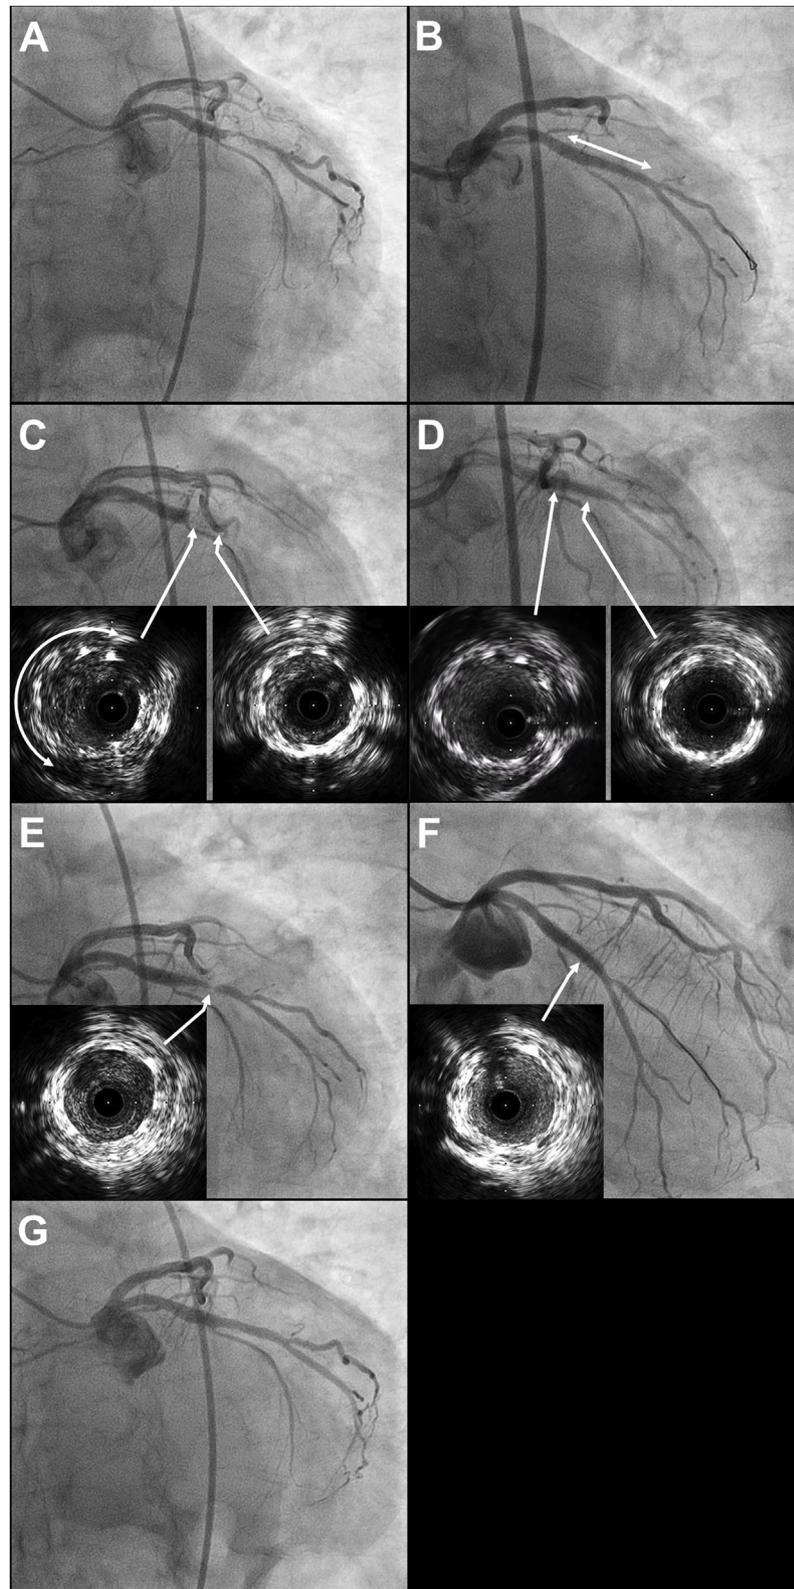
Coronary angiograms and intravascular ultrasound (IVUS) images. (A) Coronary angiography (CAG) demonstrated severe stenosis and haziness of the distal left circumflex coronary artery (LCX) at the time of ST elevation myocardial infarction (STEMI). (B) CAG after bare-metal stent (BMS) implantation in the distal LCX (double arrow) demonstrated good coronary blood flow at the time of STEMI. (C) CAG demonstrated occlusion of the BMS due to late stent thrombosis (LST) 70 days after BMS implantation. IVUS after thrombus aspiration showed good stent expansion and apposition but incomplete neointimal healing with a massive thrombus (double arrow) in the proximal portion of the stent and excessive neointimal proliferation in the distal portion of the stent. (D) CAG and IVUS after the first drug-coated balloon (DCB) angioplasty of the BMS demonstrated acceptable luminal diameter and good coronary blood flow through the stent. (E) CAG demonstrated severe binary in-stent restenosis (ISR) in the distal portion of the stent on follow-up CAG seven months after BMS implantation. IVUS showed apposition and excessive intimal proliferation in this portion of the stent. (F) CAG and IVUS after the second DCB angioplasty to treat ISR demonstrated acceptable luminal diameter and good coronary blood flow through the stent. (G) CAG did not demonstrate ISR at follow-up CAG 13 months after BMS implantation.
